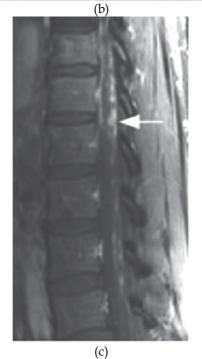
A 27-year-old male with confusion and thoracic sarcoidosis. (a) T2-weighted image shows irregular areas of increased signal intensity (arrow) at the surface of the cauda equina. (b) Axial and (c) sagittal gadolinium enhanced T1-weighted images show nodular enhancement (arrows) compatible with dural involvement.
